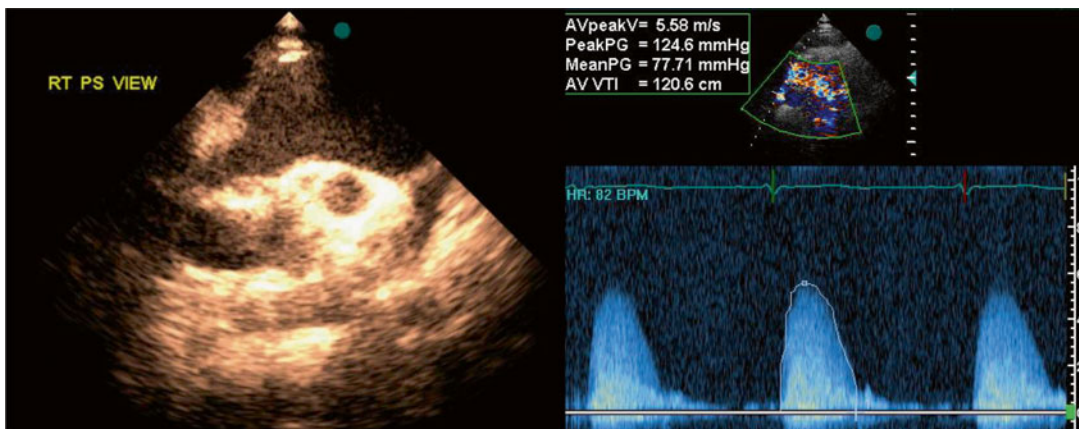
(a, b) The max gradients should be evaluated by searching in all available windows. RT PS right parasternal always should be used
